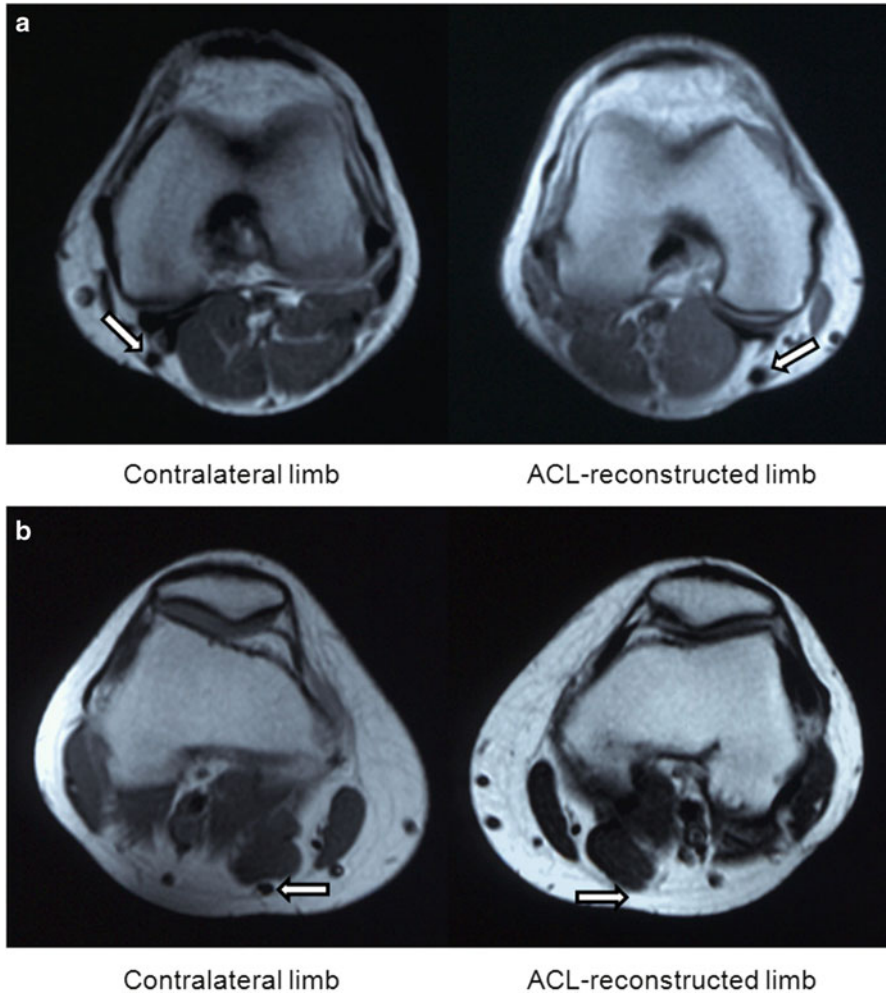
MRI of the distal musculotendinous junction (*arrow*) (Nishino et al. 2006). (a) The musculotendinous junction of the reconstructed limb shifted proximally compared with that of the contralateral limb. (b) The musculotendinous junction of the reconstructed limb was at the same level as that of the contralateral limb
